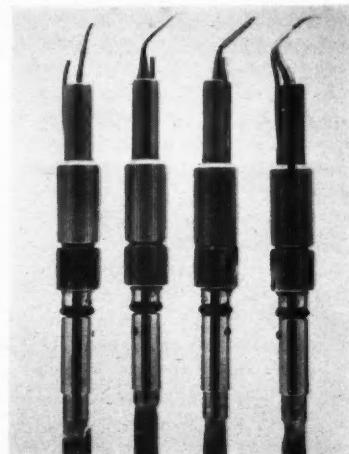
Set of ultrasonic inserts (third instrument from left has been modified for curettage).
